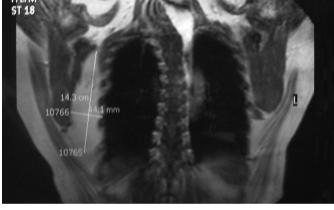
MR images of a trunk's lesion reveals the hyperintense lesionto be attached to the ribs.
